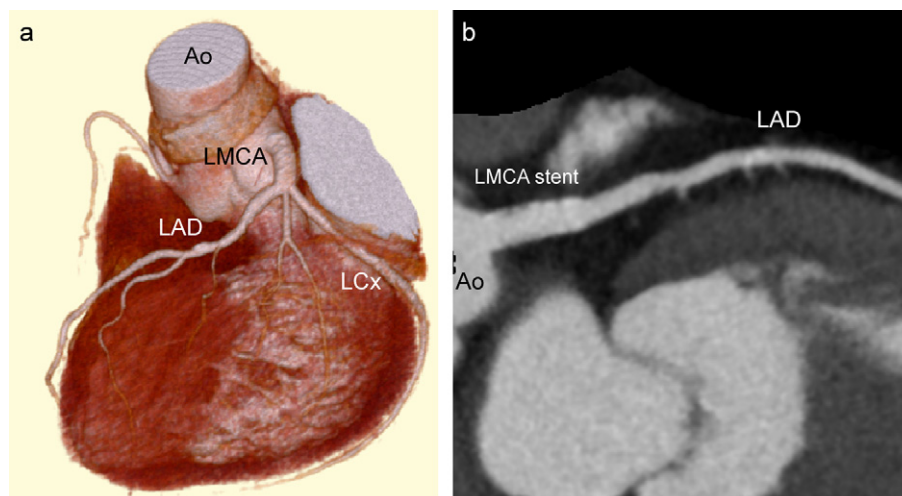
Images of multi-slice detector row computed tomography angiography at left coronary artery. (a) Volume rendered image; (b) multiplanar reconstruction image. Both images showed optimal stent apposition and no significant intimal hyperplasia in left main coronary artery at one year. Ao, aorta; LAD, left anterior descending artery; LCX, left circumflex artery; LMCA, left main coronary artery.
